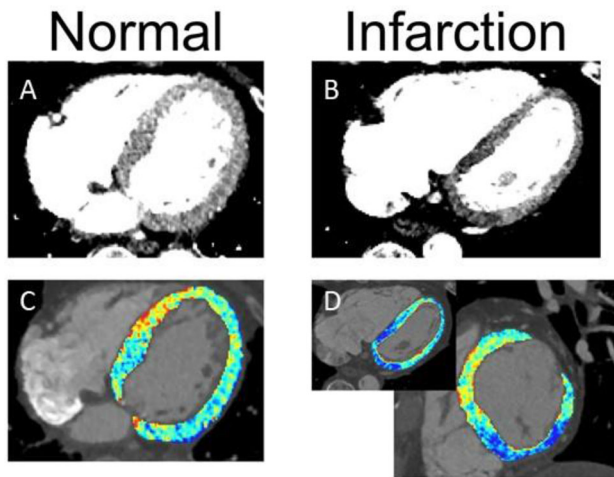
Figure showing a 4-chamber view of the heart from a double-rule out CT examinations without (A-B) and with (C-D) overlying colormaps (additional short axis view in D). A and C represent a case without myocardial abnormalities and a bland invasive coronary angiography (ICA), where B and C represent a case with transmural infarction of the inferior wall of the basis with a 100% occlusion of the RCA in the ICA.
